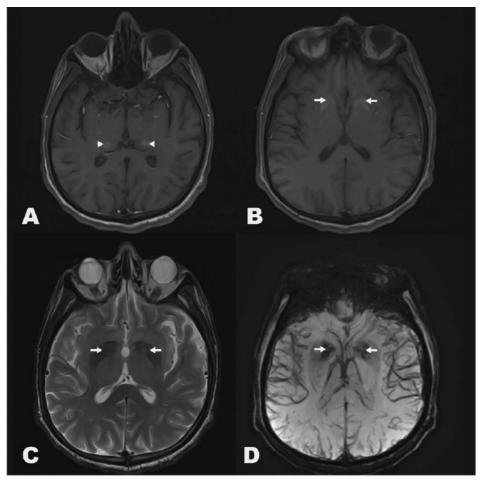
Brain MRI (axial views) showing abnormal increased bilateral basal ganglia (arrows) and thalamic signals (arrowheads): T-1 hyperintense signals(A,B); T-2 hypointense signals (C) and signal dropout (D) on susceptibility weighted image.
